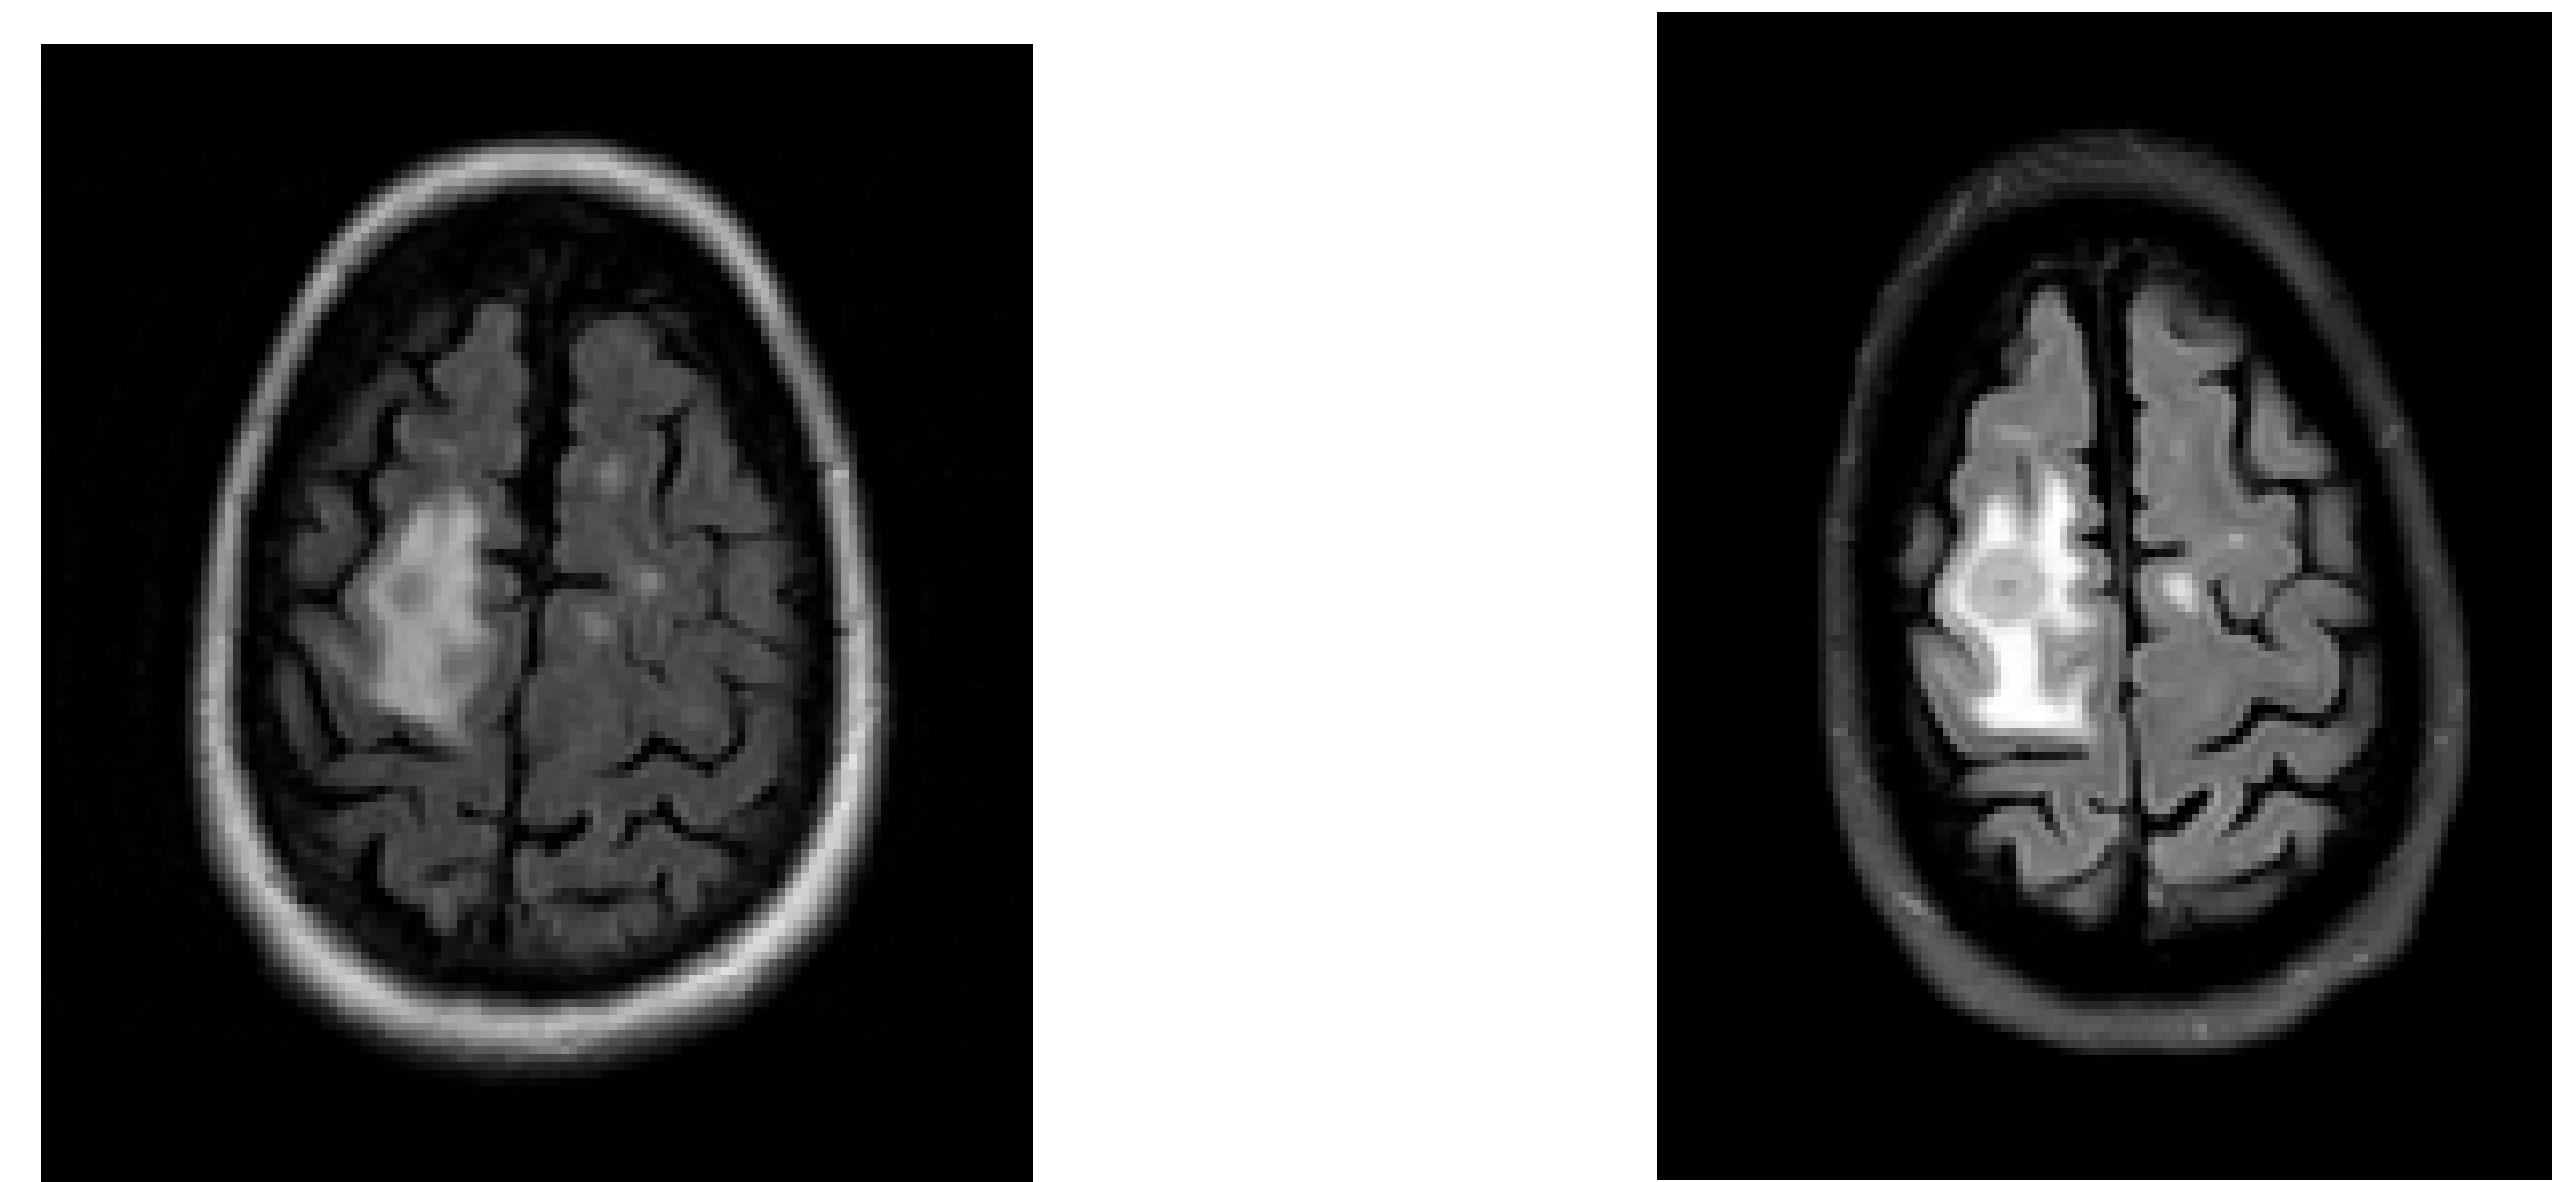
MRI T2/FLAIR images
